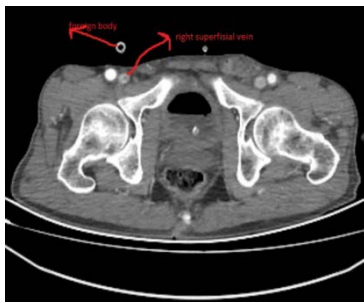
CT angiography shows intact femoral vein and artery.
